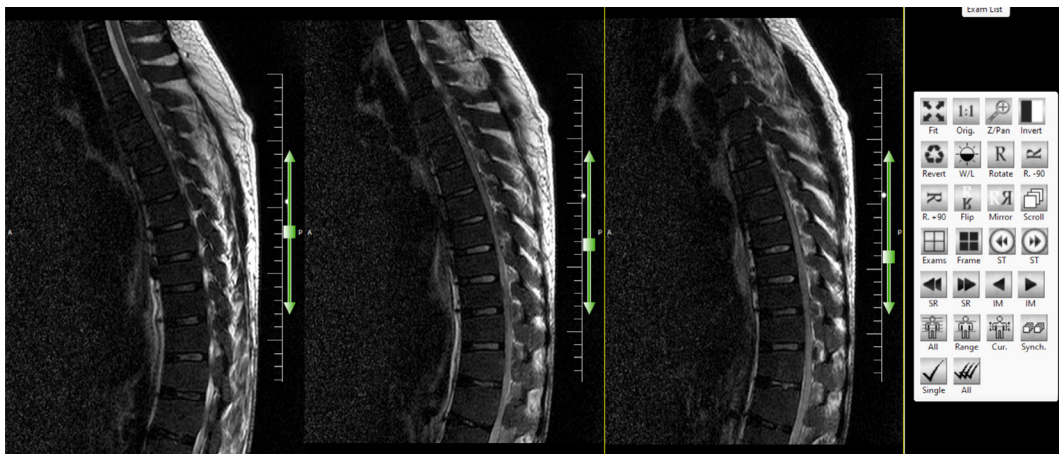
Cervicothoracic spine magnetic resonance imaging (MRI)
